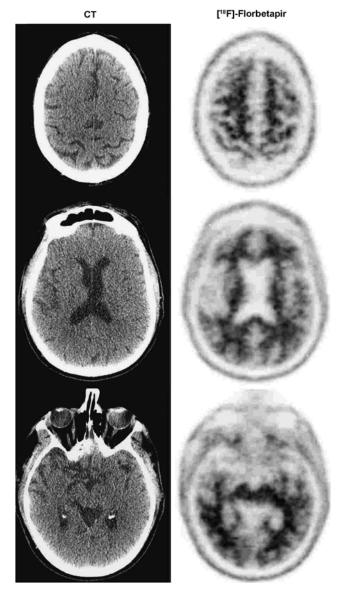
Imaging from a 71-year-old retired NFL player (case 1). Left panel is CT image and right panel is [¹⁸F]-Florbetapir PET imaging, which was negative for amyloid accumulation. CT, computed tomography; NFL, National Football League; PET, positron emission tomography.
